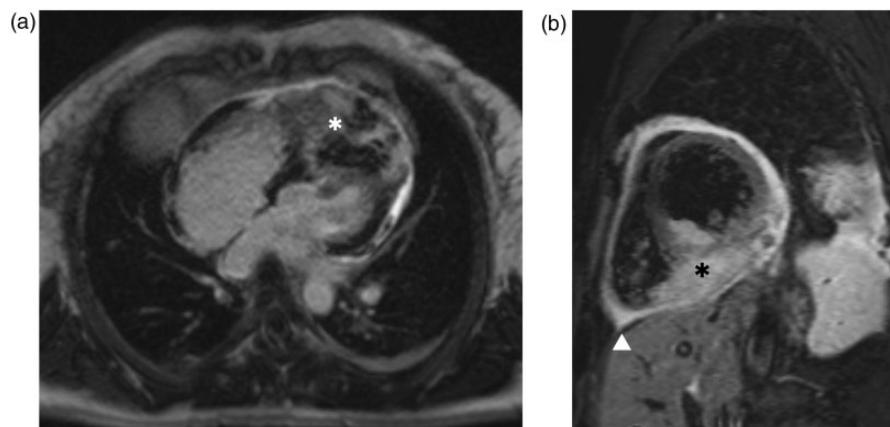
Cardiac MRI: four-chamber view of delayed enhancement image (a) and short axis view of delayed enhancement image with black-blood technique (b). The cardiac mass infiltrated the right and left ventricular myocardium and cavities (asterisks). Images also show pericardial effusion and thickening (arrow head).
